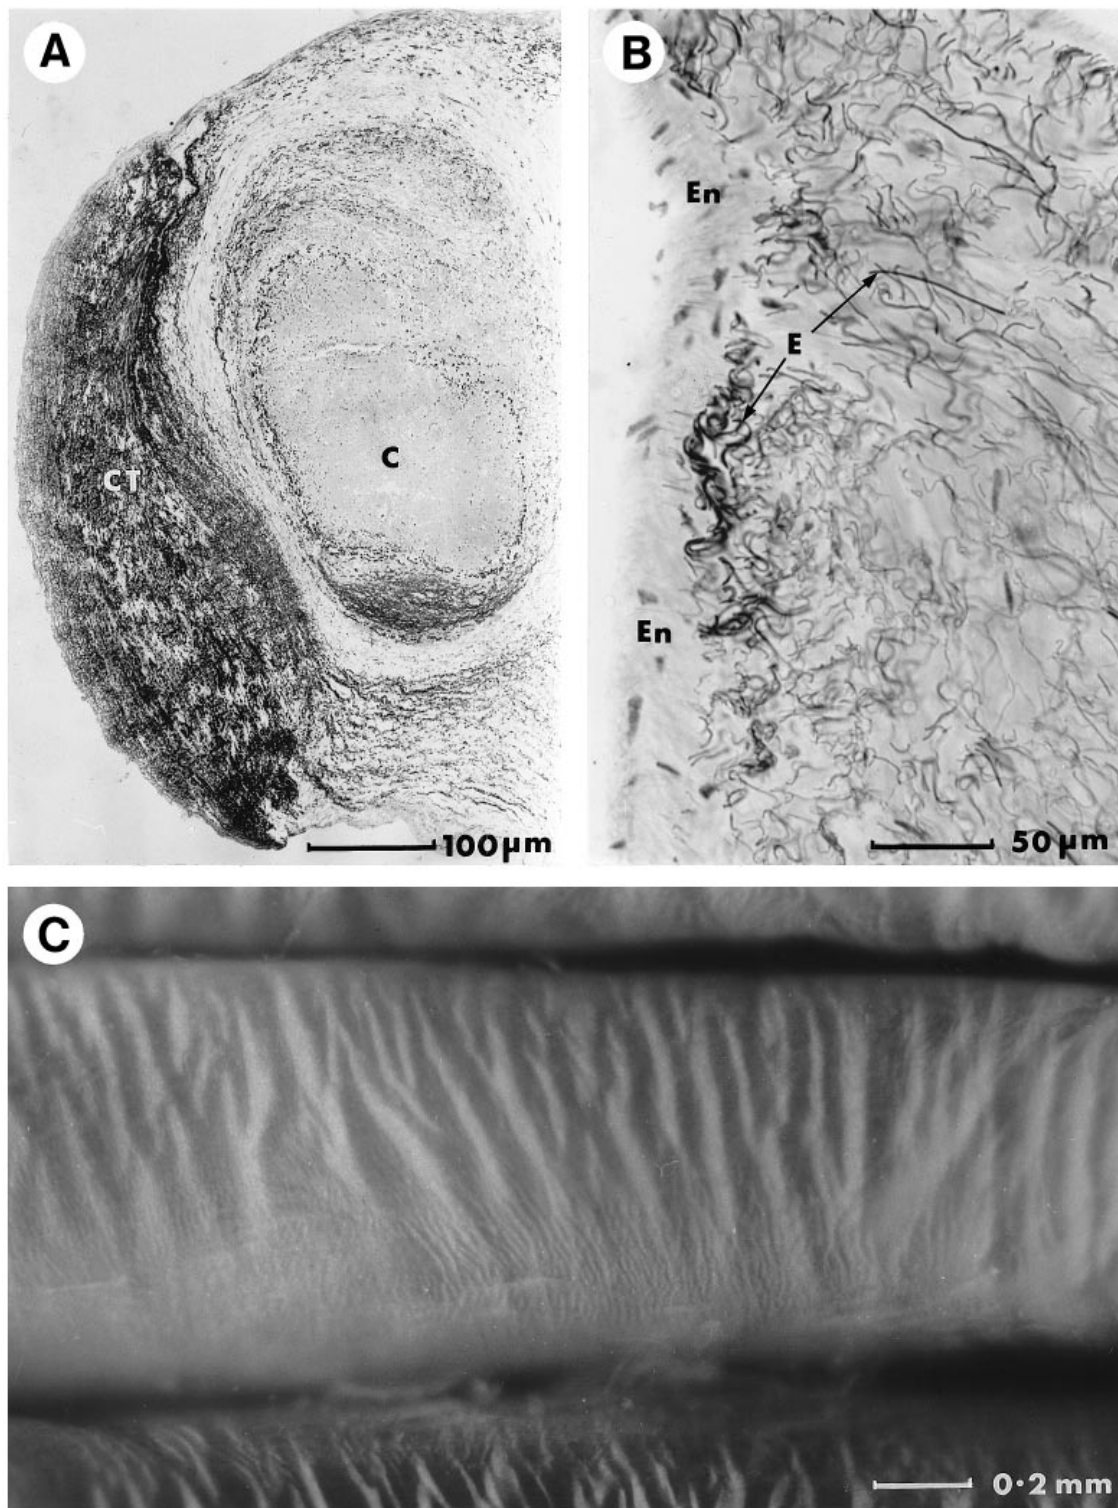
(A) Cross-sectioned chorda originating from an elderly subject showing an extensive cushion of subendocardial connective tissues (CT). $\times 169$. C, collagen core of the chorda. (B) Enlarged fragment within the connective tissue cushion showing disorganised network of elastic fibres (E). $\times 322$. En, endothelium. (C) Reflected image from a chorda of an elderly subject showing a patch of $17\text{ }\mu\text{m}$ period regular stripes (compare with Fig. 2A) surrounded by disorganised region with a broad striped pattern. $\times 67$.
